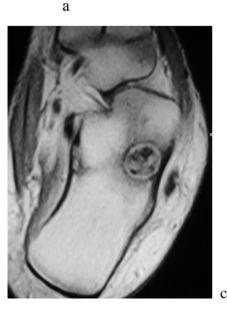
Osteoblastoma. Radiography (a) shows an ill-defined lytic lesion and peripheral sclerosis (arrow). MRI T2W (b) and T1W (c) show well defined nidus (arrow), larger than 1.5 cm with extensive surrounding edema, consistent with the diagnosis.
